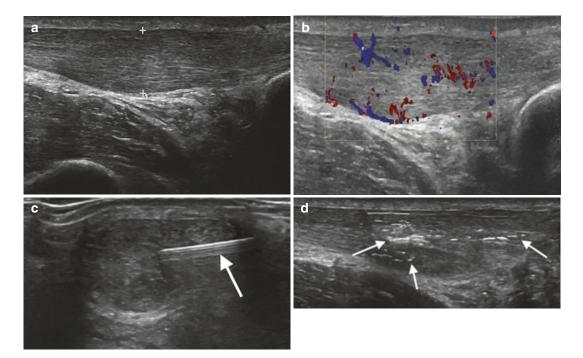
A 52-year-old male with Achilles tendinosis with limitation activity and pain on compression of the mid-Achilles. (a) Longitudinal ultrasound demonstrates mid AT tendinosis with (b) increased internal flow on
